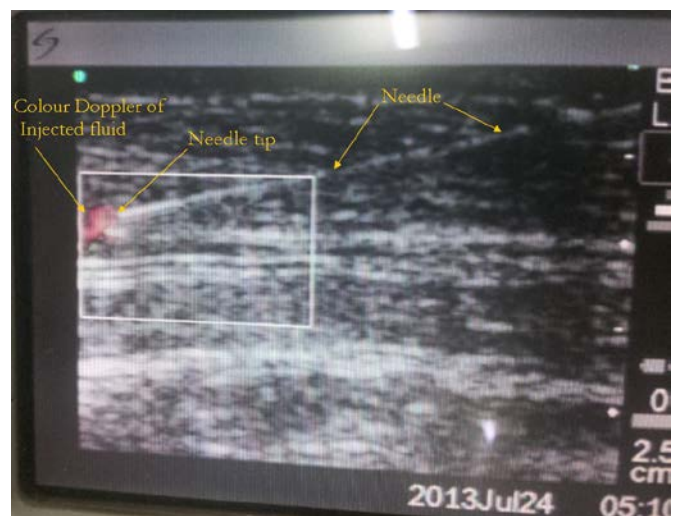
Colour flow Doppler image of needle.
